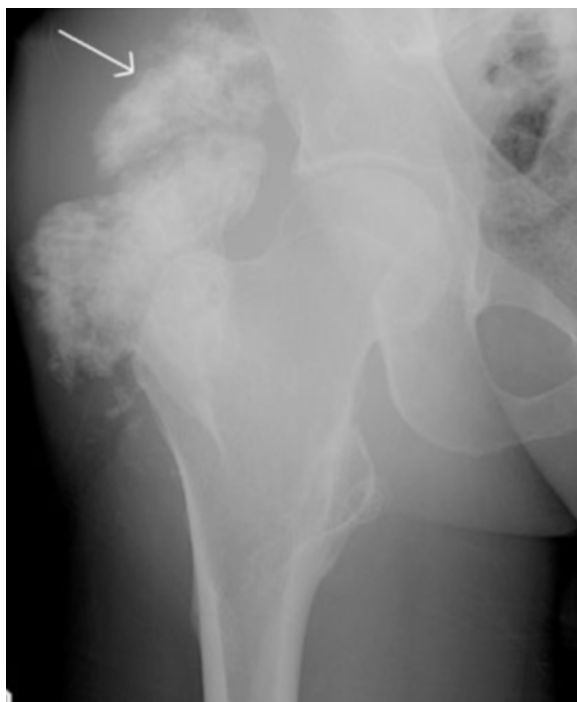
39-year-old man with multiple hereditary exostoses and enlarging right hip mass. Radiograph shows soft tissue calcification adjacent to an exostosis arising from the greater trochanter, extending superiorly into the right gluteal region (arrow).
